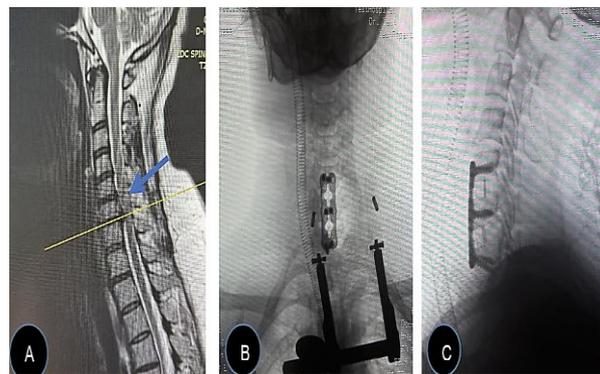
A) Preoperative sagittal magnetic resonance imaging (MRI) with an image of cervical stenosis at levels C5-C6; B) Postoperative axial fluoroscopic image with a view of the anterior cervical plate; C) Lateral fluoroscopic control image with a view of the inserted cervical plate
